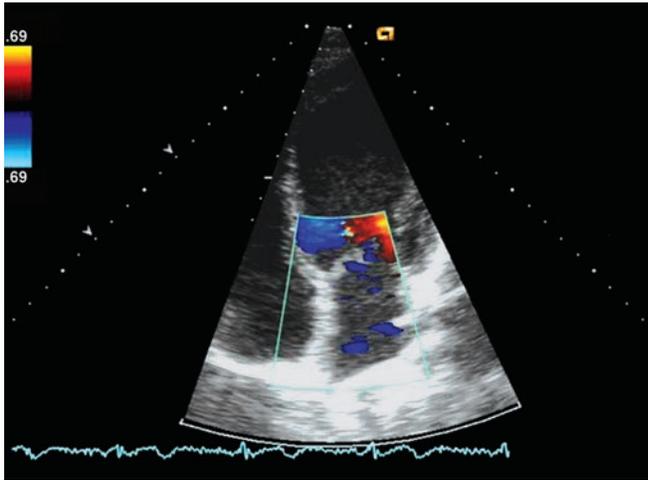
Doppler of mitral valve.
